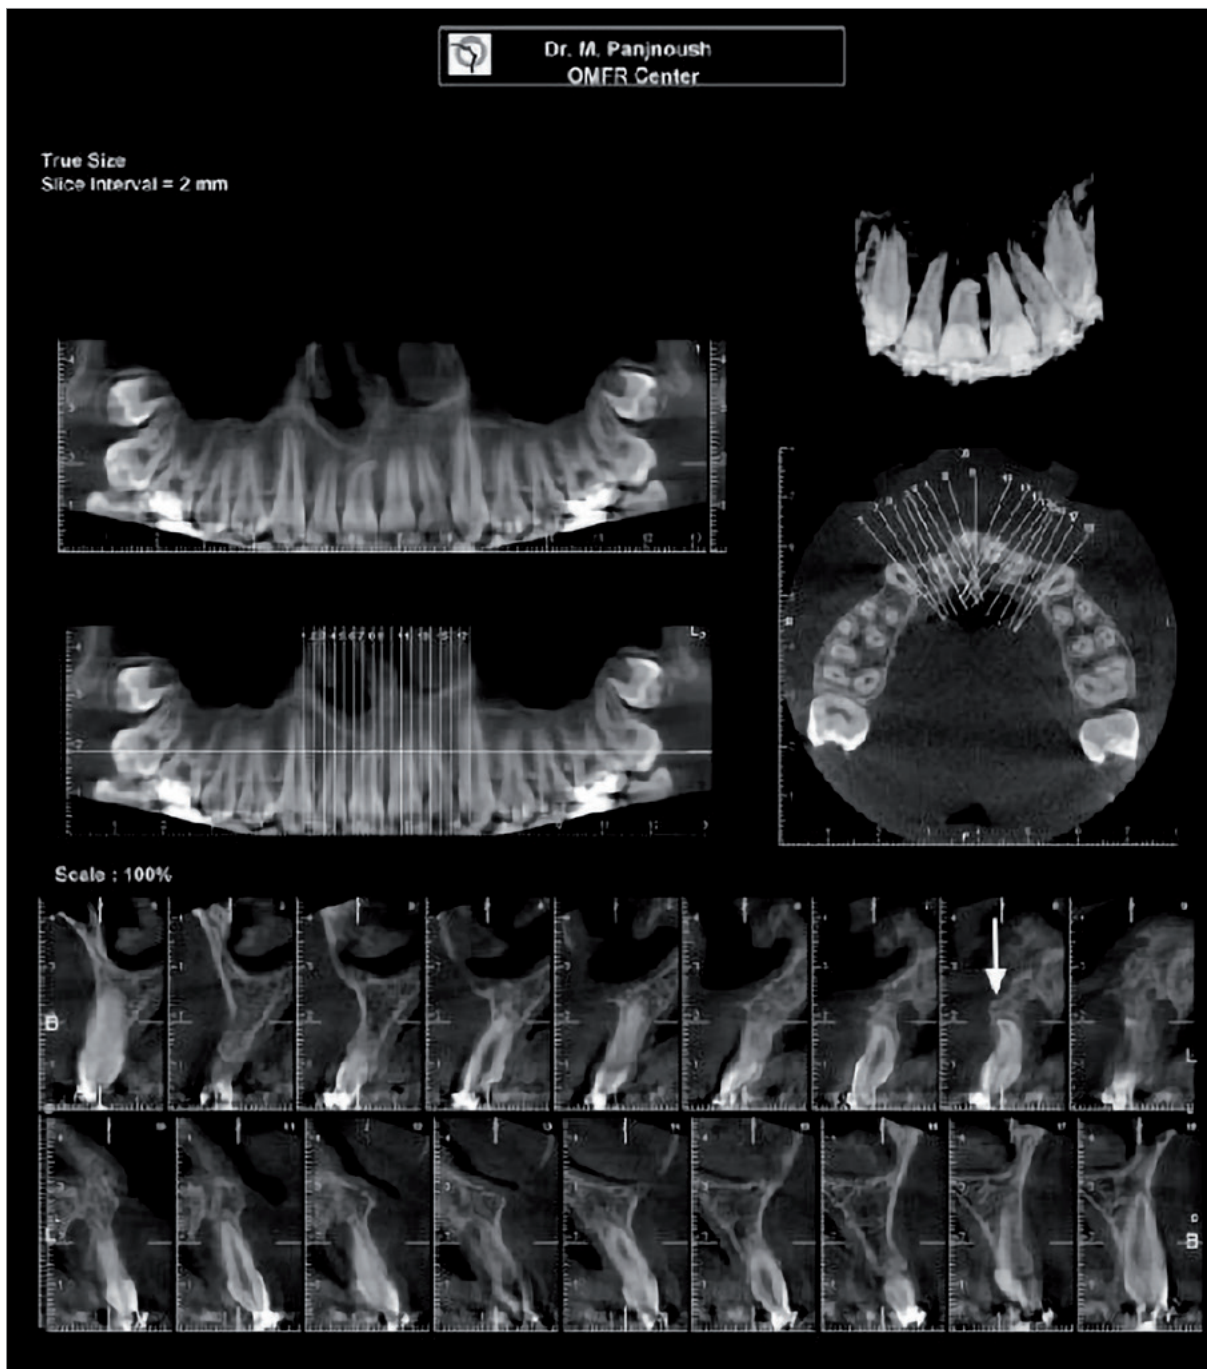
CBCT scan showing the proper position of the impacted tooth with a favourable gingival margin, minimal root resorption and an acceptable amount of surrounding bone.
